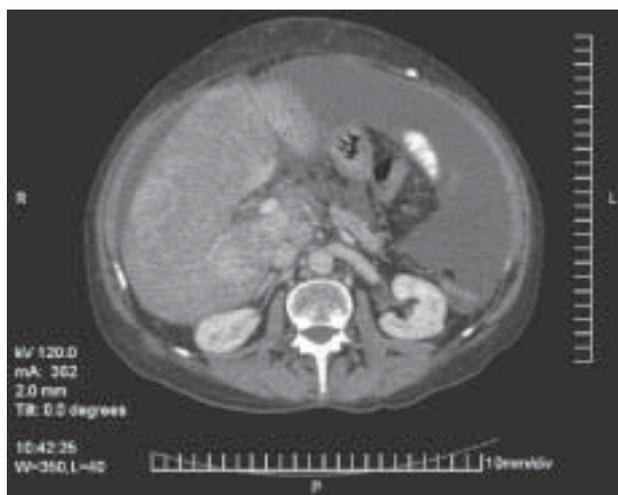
Carcinoid hepatic metastases (CT scans, March 2009)
